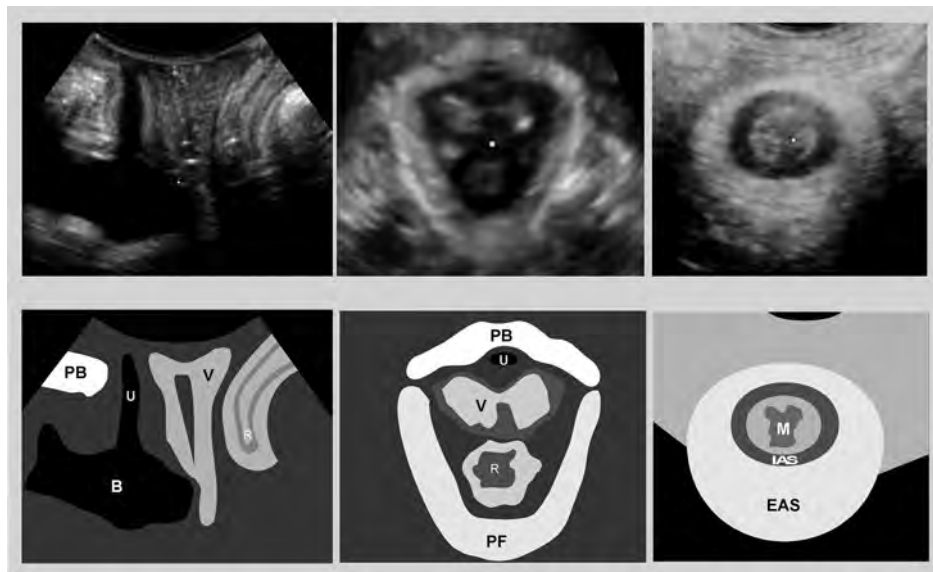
Transperineal ultrasound
